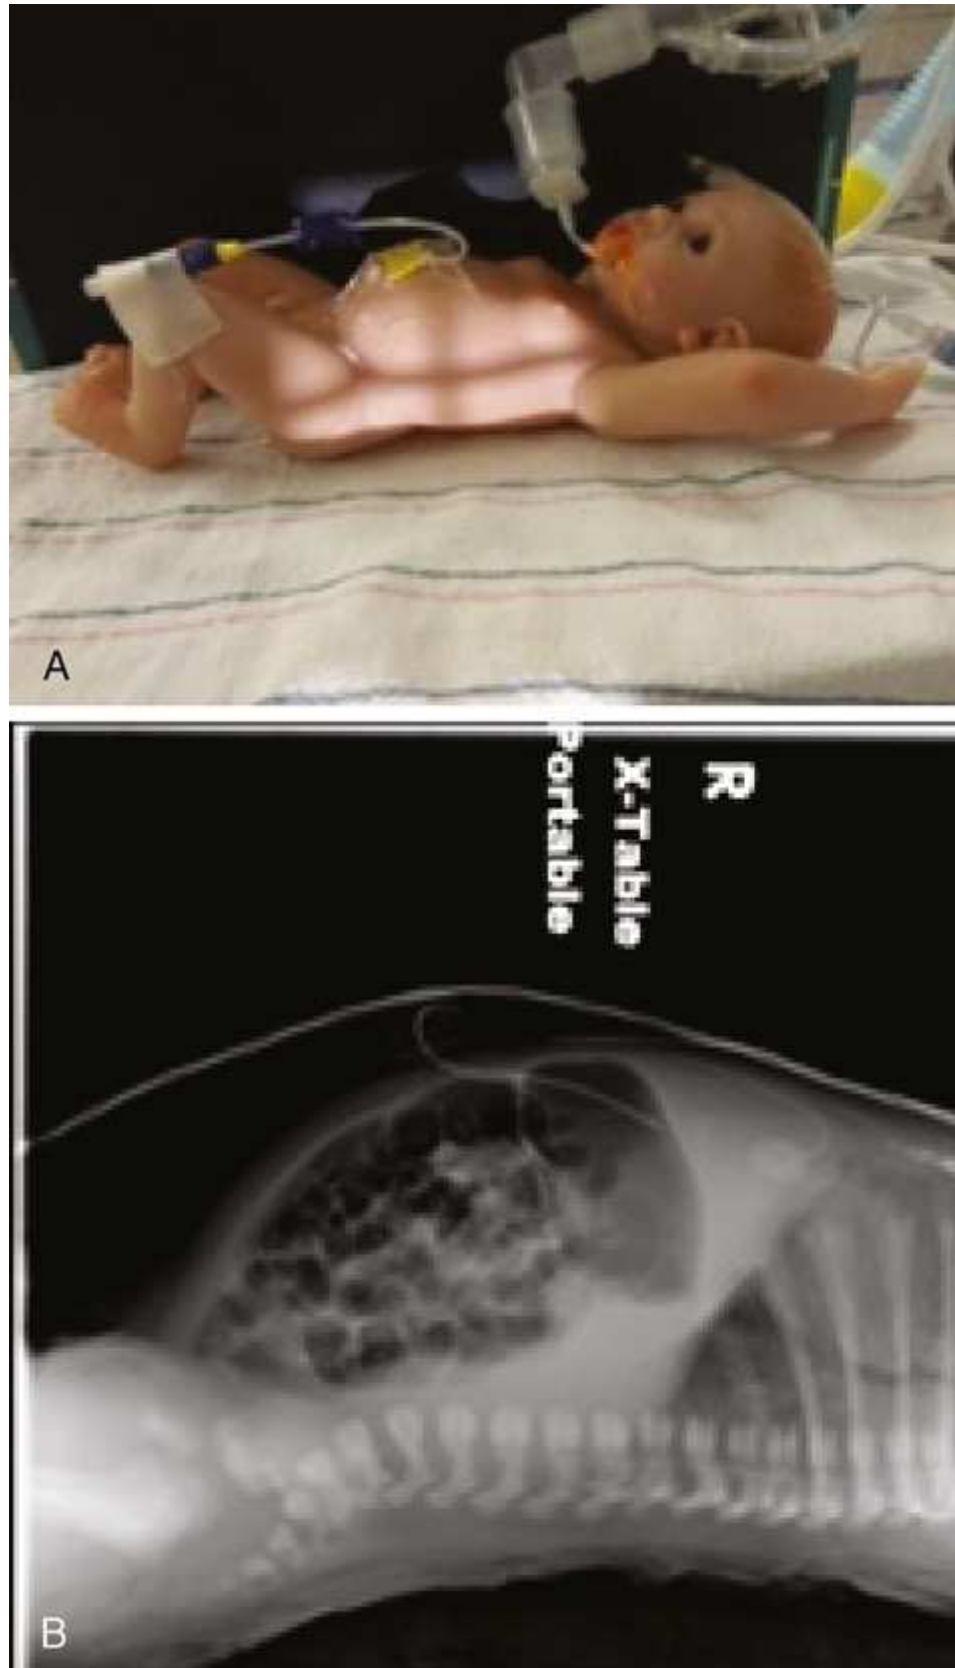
(A) Right lateral dorsal decubitus abdomen position. (B) Right lateral dorsal decubitus abdomen radiograph.
